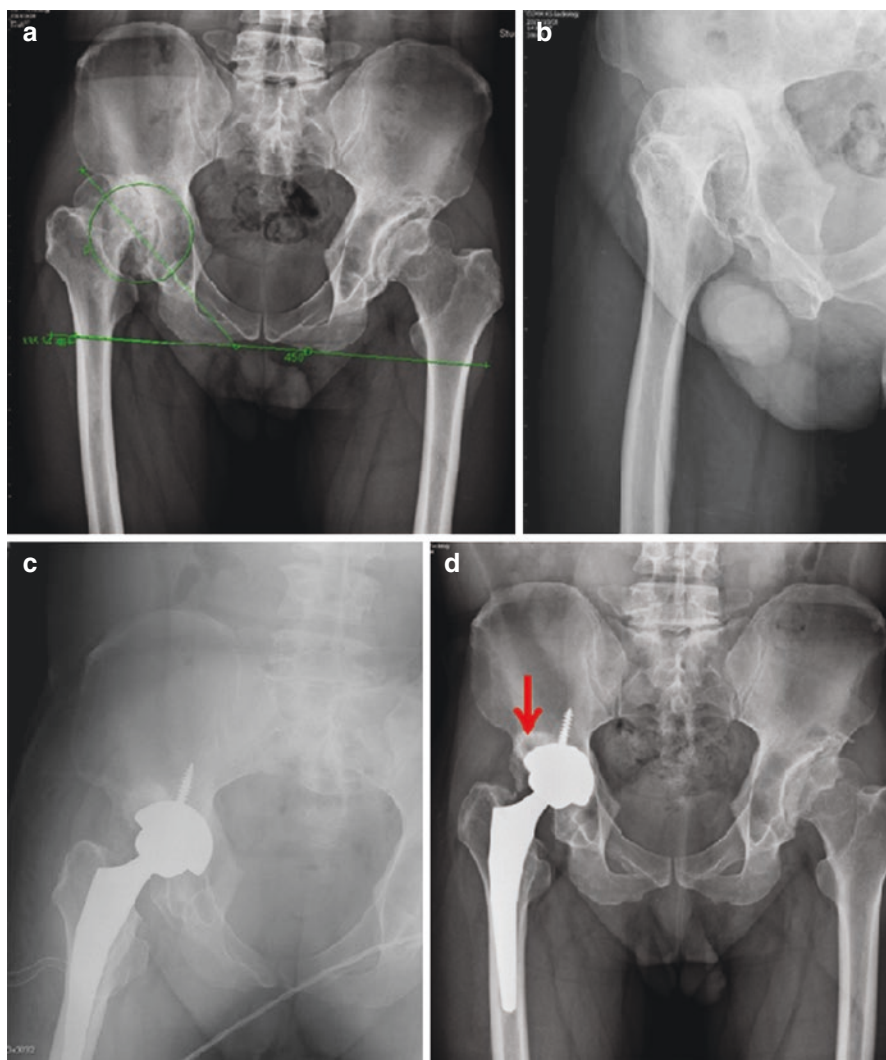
A 42-year-old man with bilateral DDH and with secondary arthritis. Plane radiographs showed a Paprosky type IIB acetabular defect of the right hip (a and b). Immediately postoperative radiograph showed a superomedial placement of the socket and morselized grafts on the lateral wall (c). Radiograph performed 3 years after the operation shows the optimum position of the acetabular socket, good healing of autografts (arrow), good bone ingrowth of both components, and good leg length restoration (d) (these pictures were agreed by the patient for publication)
